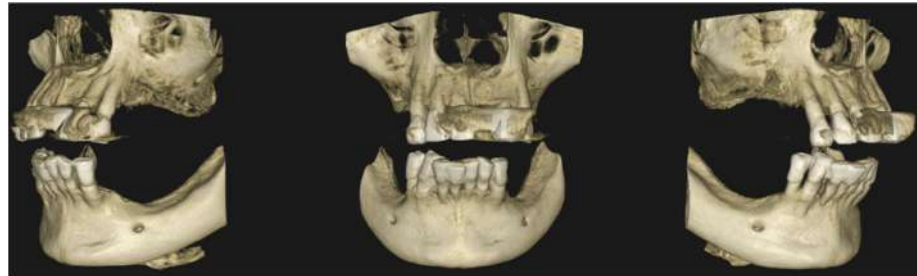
3D reconstruction of the CBCT scan.
